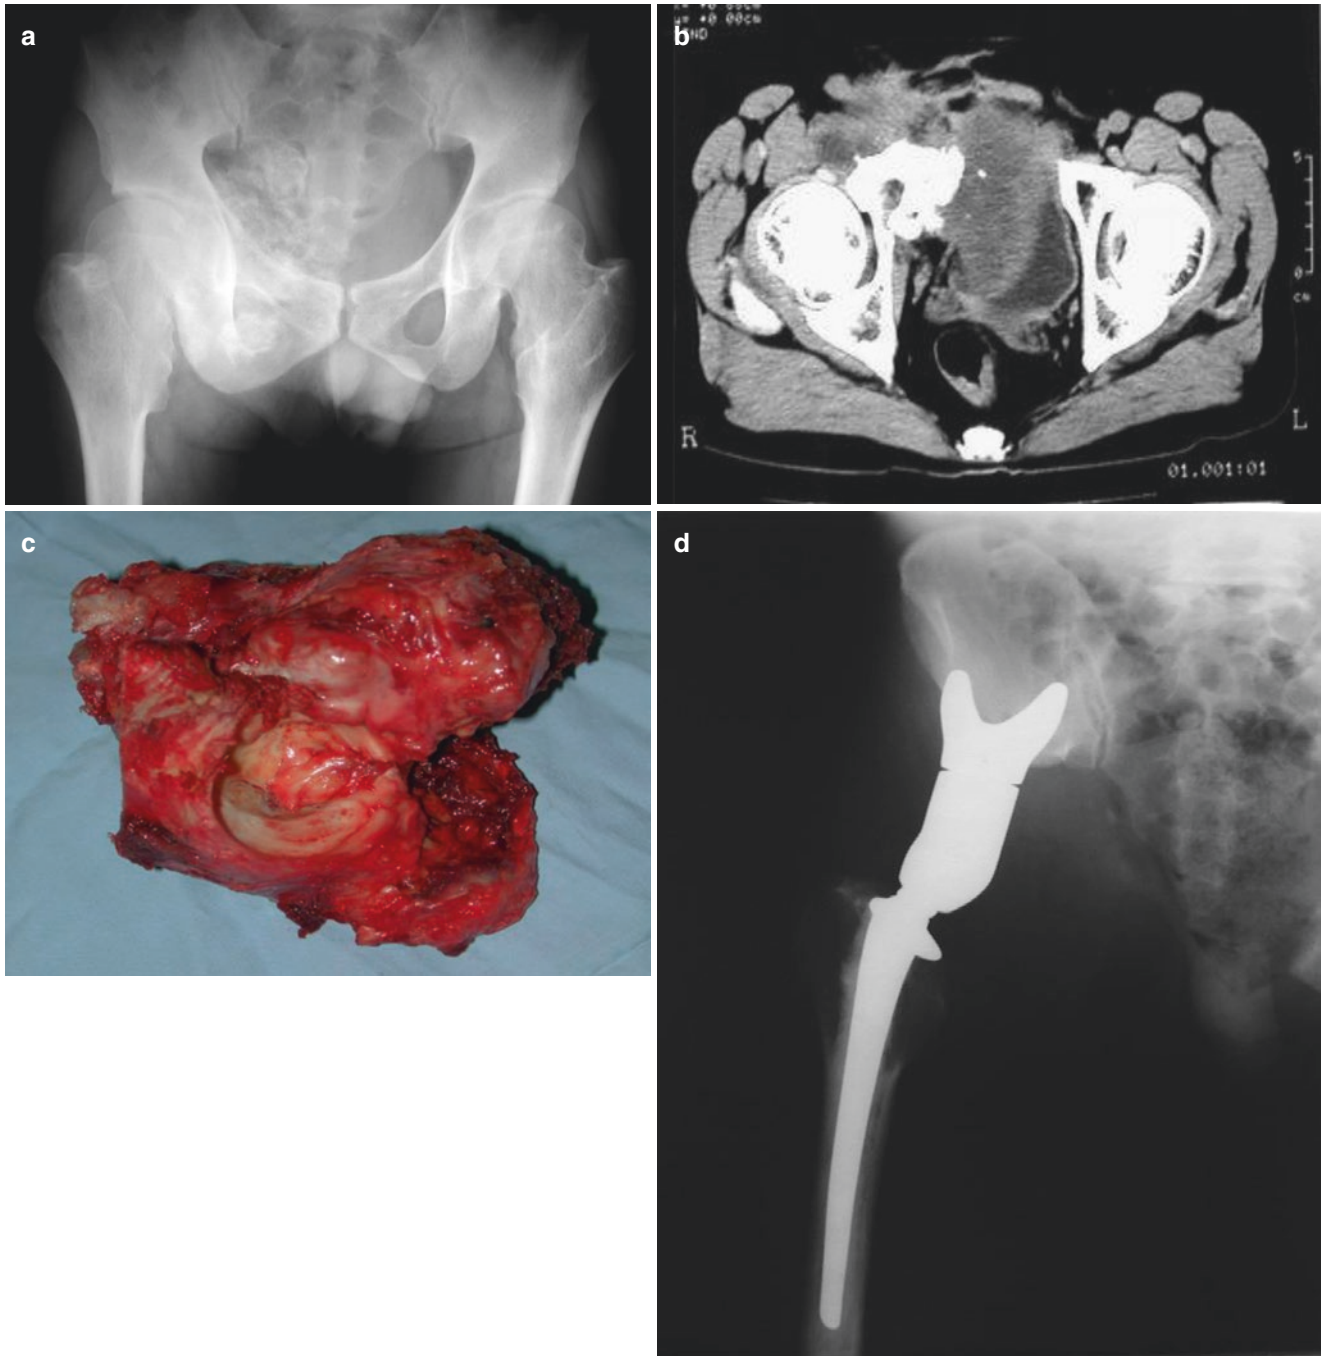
The patient was a 34-year-old male with chondrosarcoma in the right pelvis involving the acetabulum, pubis, and ischium. Preoperative radiography (a, b) showing the tumor mass. (c, d)
